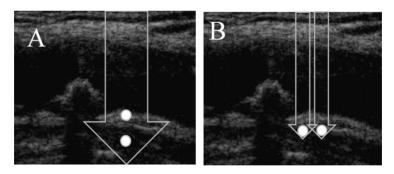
Axial resolution (A) differentiates between superficial and the deeper structures. It is directly dependent on the frequency of the ultrasound transducer (higher frequency = higher axial resolution). Lateral resolution (B) is the ability of the equipment to differentiate two adjacent structures. It depends on the beam width.
